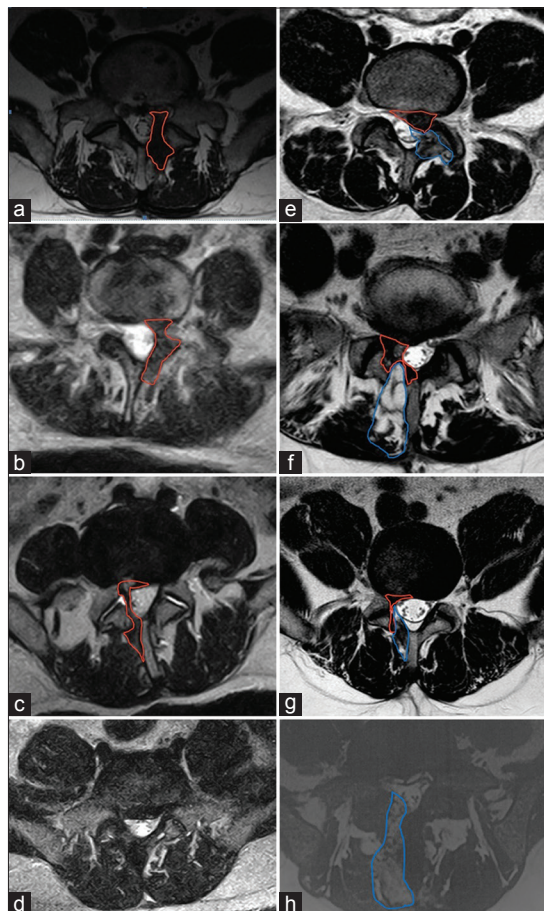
Axial MRI T2W images at the level of surgical access. (a-c) Patients operated without autologous graft-fat with evidence of scar tissue formation (red line). (d) Patient operated without autologous graft-fat without sign of scar tissue. (e-g) Patients operated with positioning of autologous fat-graft (blue line) and evidence of scar formation (red line) (h) Patient operated with positioning of autologous fat-graft (blue line), without sign of scar tissue formation
